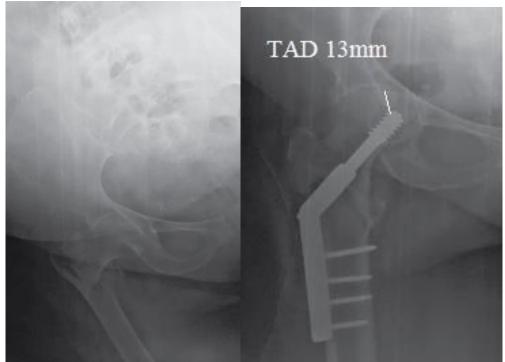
(A) Plain x ray Showing fracture right hip intertrochanteric (B) postoperative X-ray demonstrating DHS fixation of the fracture.
